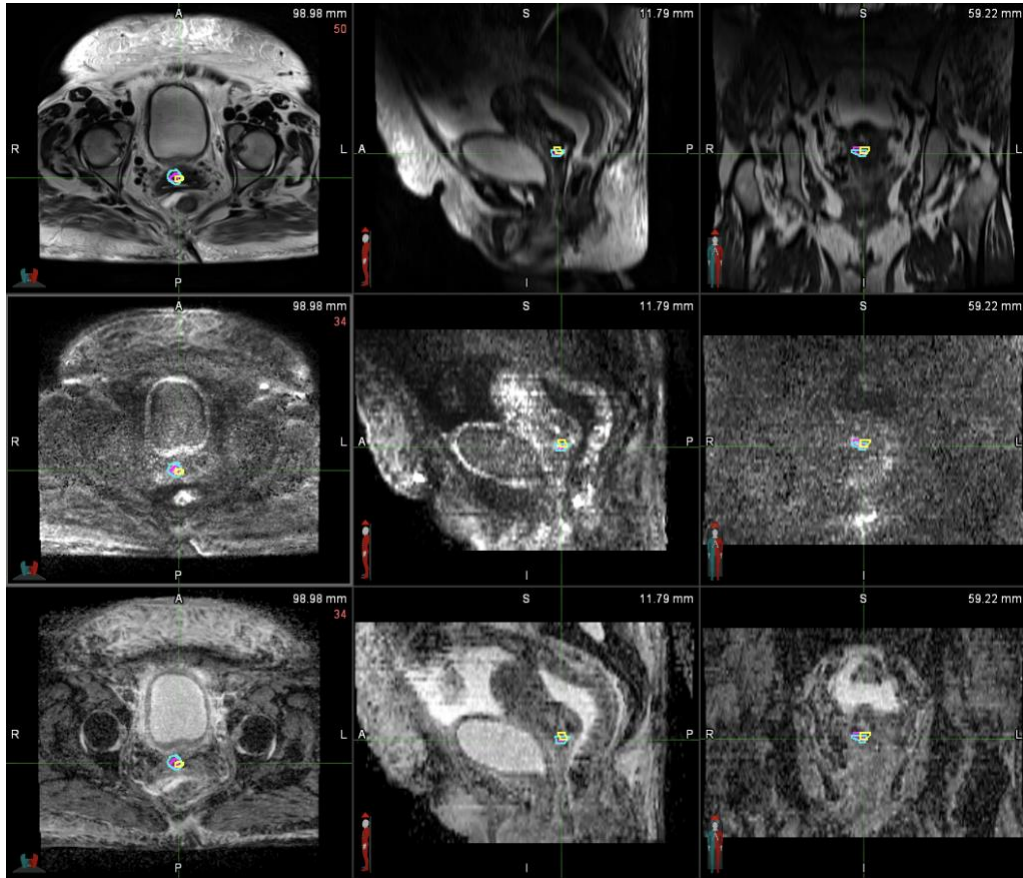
Example slice from Patient 5's a) pre-EBRT scan and b) pre-brachytherapy scan with the overlaid GTVs. The image rows from top to bottom for both scans are T2 MRI, ADC, and DWI. The GTVs contoured with the axial T2 MRI, with the axial T2 MRI/DWI fusion, and with the axial T2 MRI/ADC fusion are magenta, cyan, and yellow, respectively.
